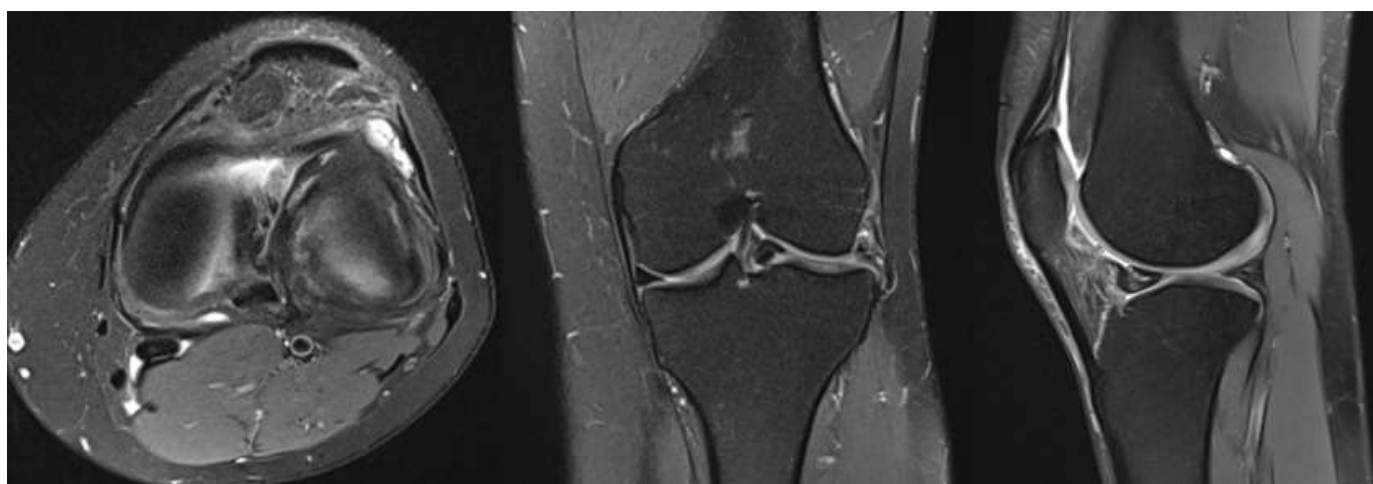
MRI transverse (left), coronal (centre) and sagittal (right) plane view.
